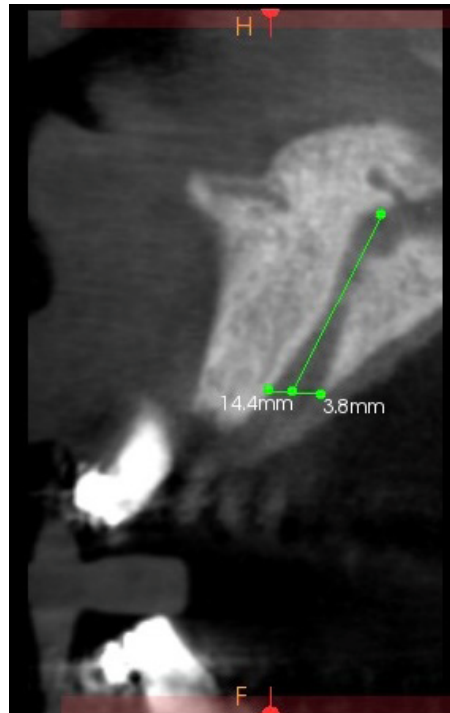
Sagittal slice of CBCT image showing landmarks for determination of length of NPC and diameter of incisive foramen.
